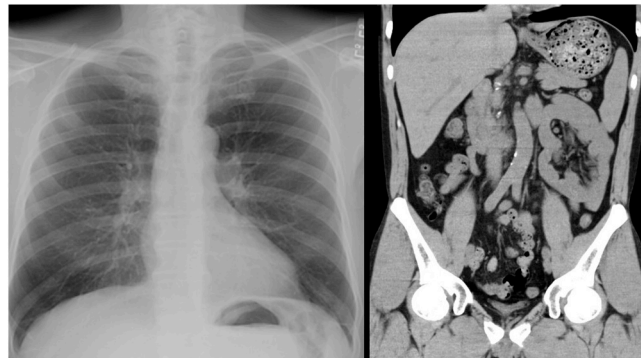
Image findings of chest X-rays and Computed tomography.
